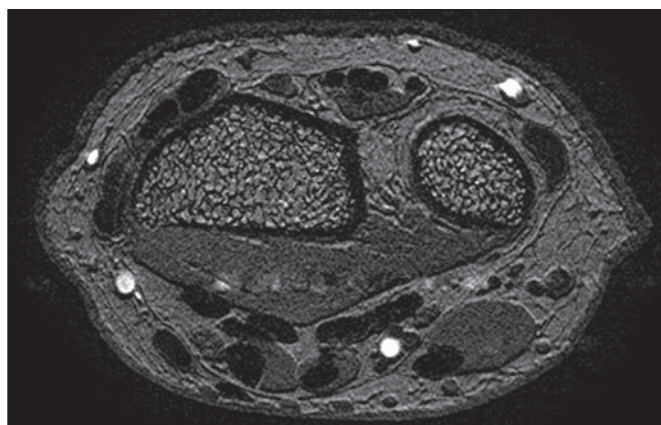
Example of axial MR image acquired for trabecular bone characterization in 24-year-old healthy man. Acquired isotropic spatial resolution of $180 \mu\text{m} \times 180 \mu\text{m} \times 180 \mu\text{m}$ is achieved.
